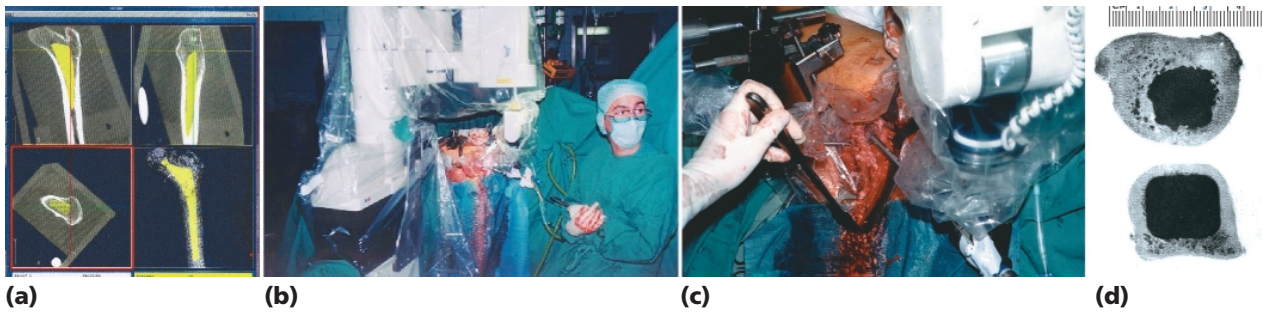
The Robodoc system. (a) A screen of Orthodoc, the preoperative planning module. Three windows show orthogonal cross sections of the CT; the fourth (lower right) shows a 3D reconstruction of the femur. The yellow shape is the implant, which the surgeon has chosen and positioned before the surgery. (b) The six-axis robot covered by a sterile protection drape. The machining tool (in the center) is tilted to provide better access to the exact place on the femur canal. (c) Robodoc in action: the robot milling the femoral canal. (d) Cross sections of a manually cut femur (top) and a robotically machined femur (bottom), which has superior surface finish and fit. (Photos courtesy Integrated Surgical Systems.)
